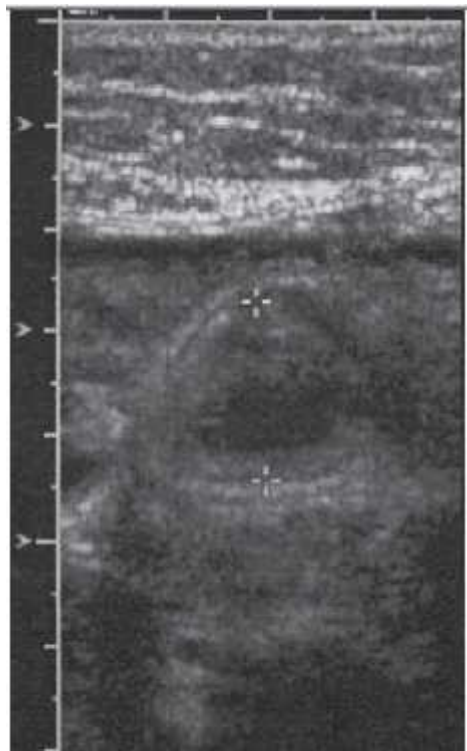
Appendiceal ultrasound showing distended non compressible appendix measuring 1.7 cms in transverse dimension¹¹
